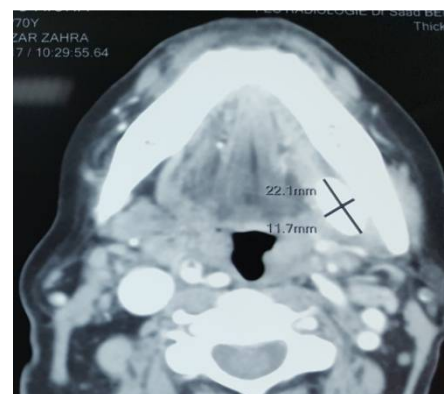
Axial CT scan showing a giant sialolithiasis of the submandibular gland.
